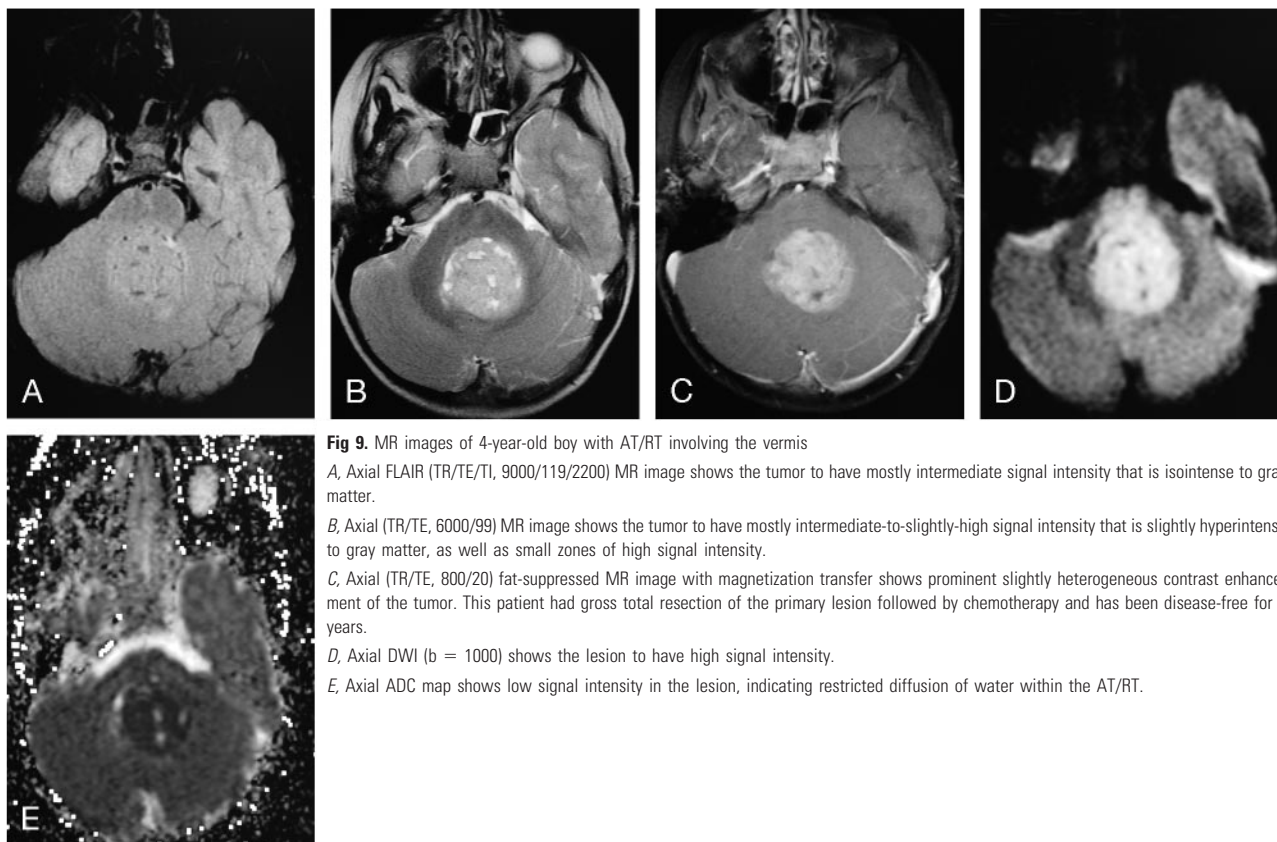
MR images of 4-year-old boy with AT/RT involving the vermis
